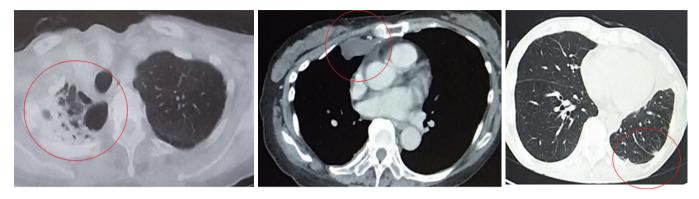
Postoperative changes. Computed tomographic (CT) images showing postoperative changes, but not recurrence. Radiographic diagnosis of recurrence can be difficult in postoperative chest CT because of postoperative changes.
